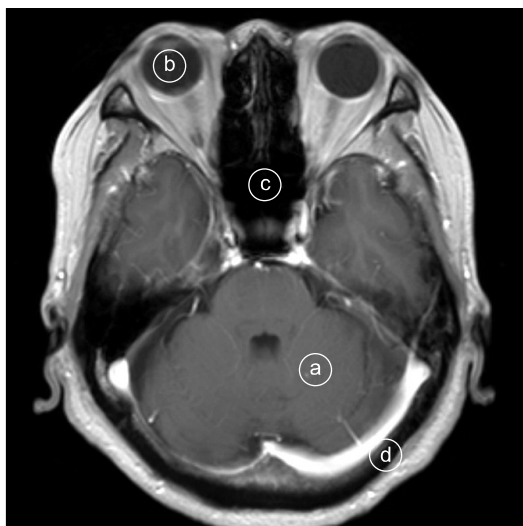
The OARs are contoured on the magnetic resonance images (MRI) in order to define the gray scales; (a) The brain soft tissue, (b) Eyeball, (c) Nasal cavity, and (d) Bone.
